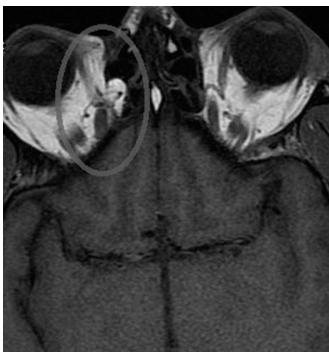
Axial T1 MRI image demonstrating right medial wall defect and intraorbital contents within the ethmoid sinus.
